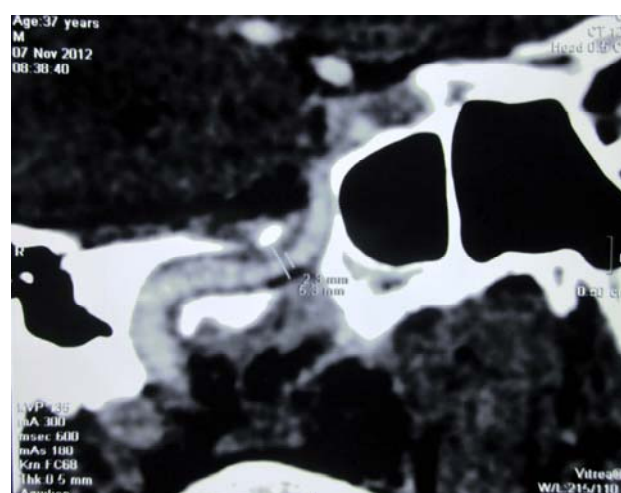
Multislice computed tomography (MSCT) angiography of the brain. A petrous segment of the right internal carotid artery narrowed approximately 60%.
